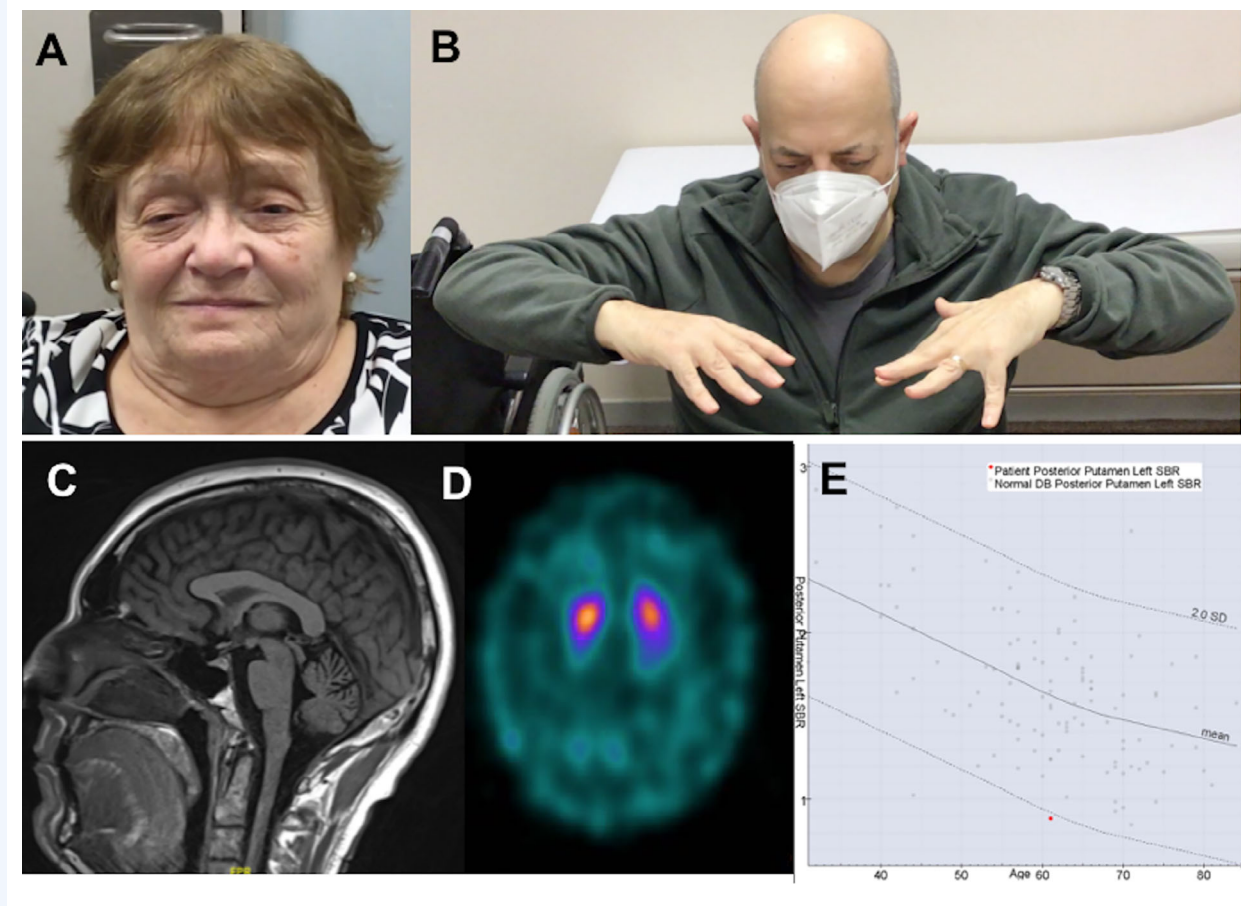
Clinical and radiological findings in SCA36. (A) Bilateral ptosis in a patient that also displayed ophthalmoplegia; (B) Left-hand dystonic postures in a SCA36 patient with dystonic tremor. (C) Sagittal T-1 weighted MRI imaging showing cerebellar atrophy. (D) 123-Ioflupane reveals bilateral asymmetrical denervation with right striate reduced uptake. (E) Semiquantitative analysis with DaTQUANT™ for left posterior putamen confirms a decline (red spot) in tracer uptake compared to mean tracer uptake for age-matching healthy controls.
